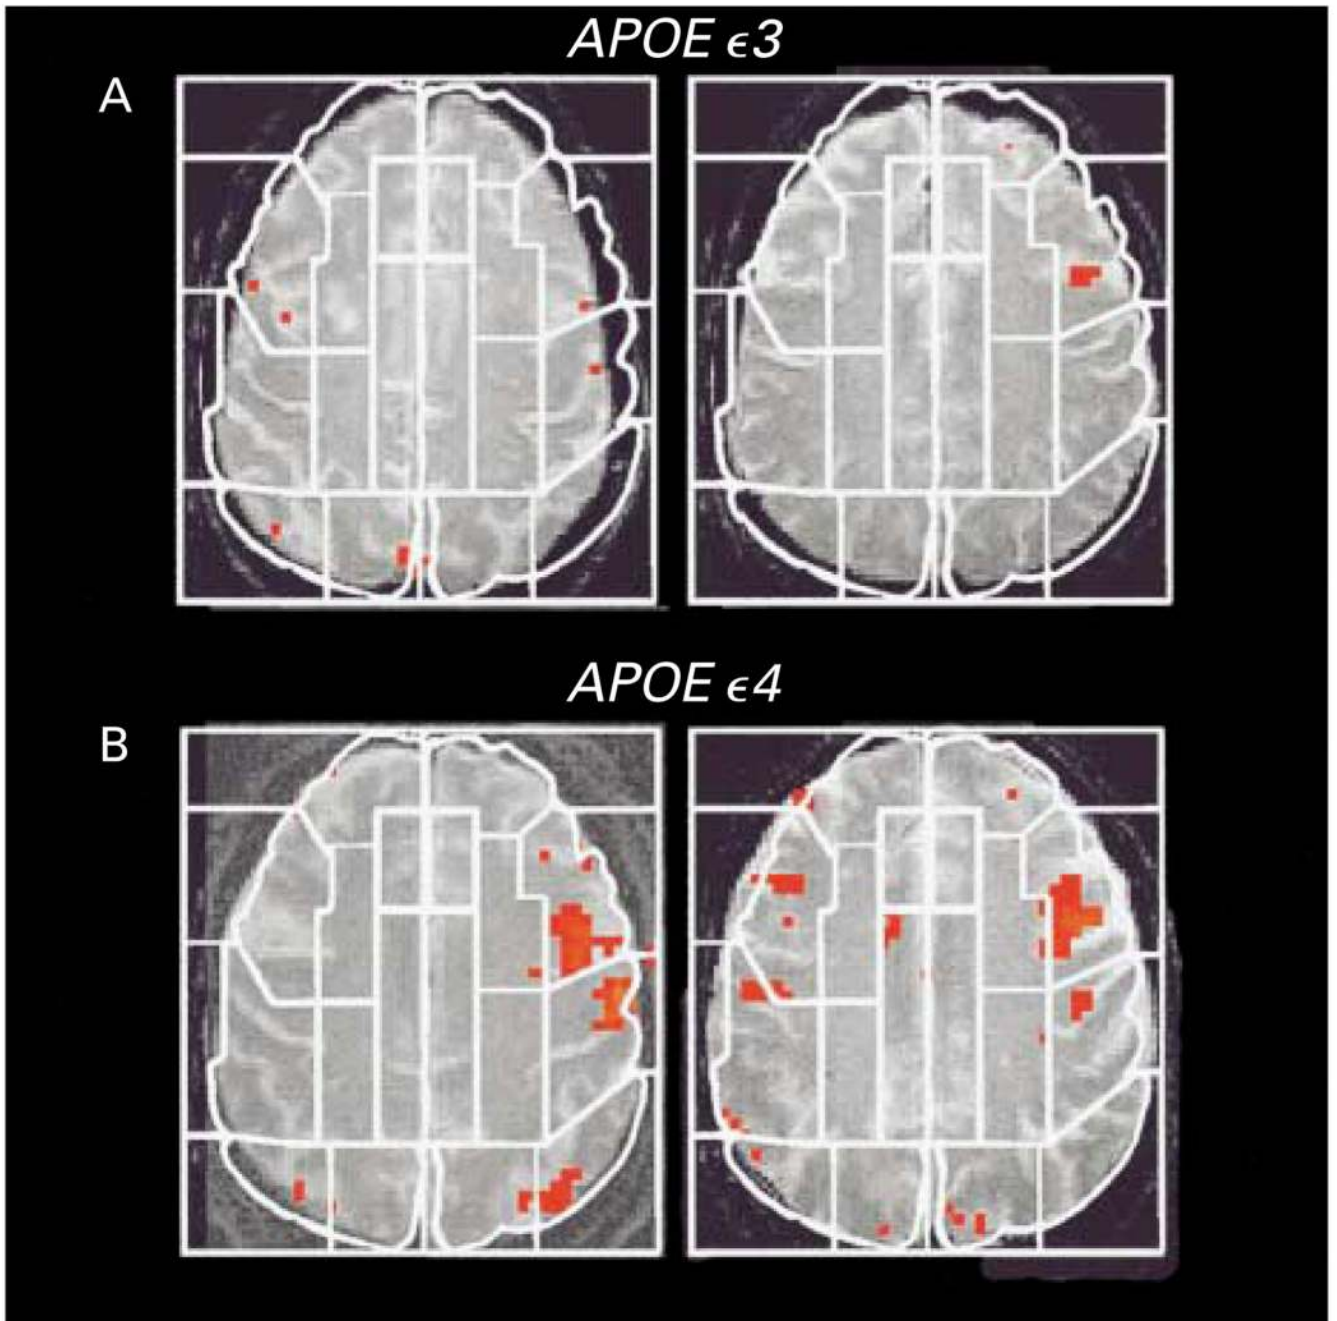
Examples of Activation Maps on Single MRI Planes
